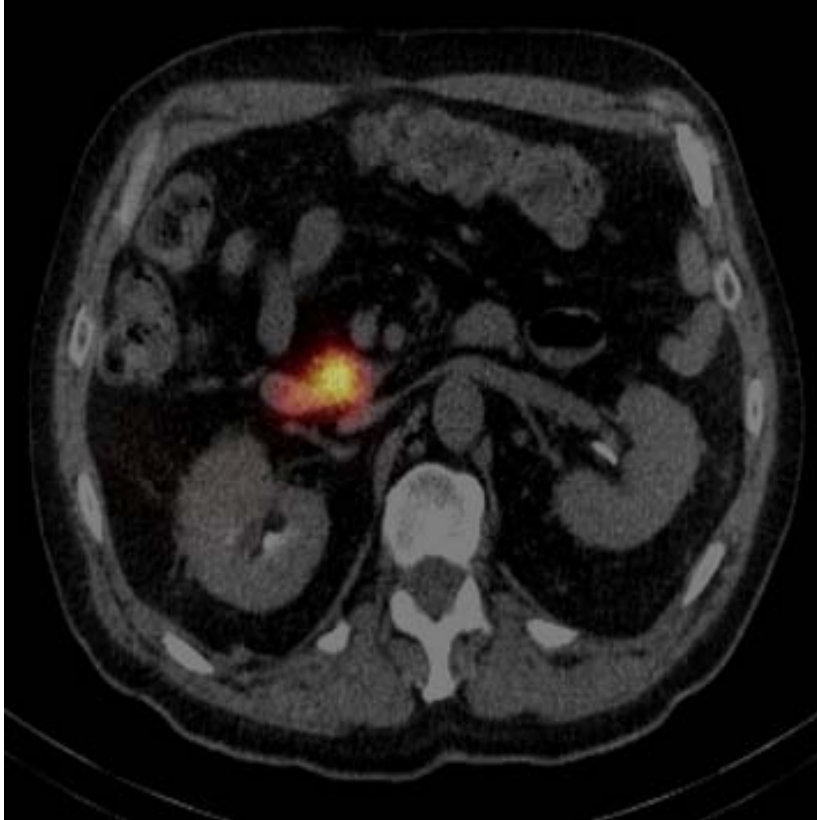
63-year-old male with colon carcinoma metastatic to the liver was administered 85.1 MBq of ^{99m}Tc -MAA through a catheter placed in right hepatic artery proximal to the gastroduodenal artery; seventy-five minutes following administration, SPECT/CT study was performed. The transaxial slice from the reconstructed SPECT/CT image showed activity in the second portion of the duodenum.
